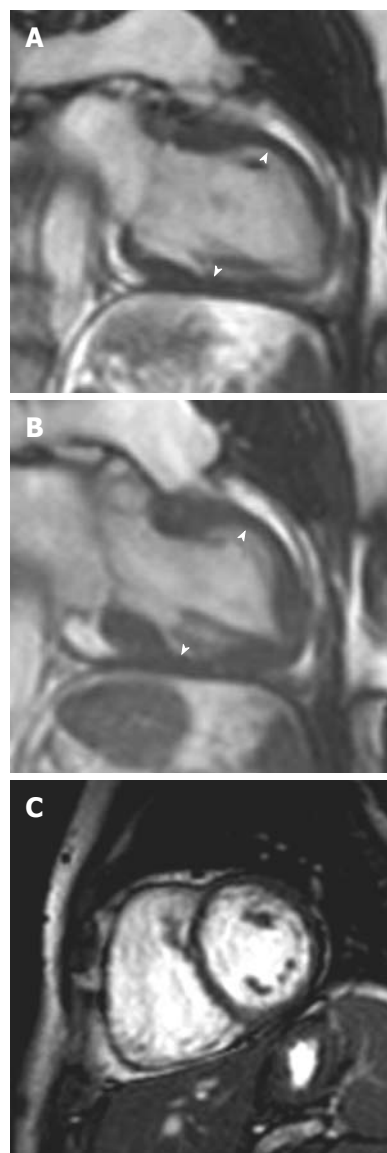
A 54-year-old woman with acute onset chest pain and palpitations following a road traffic accident. A, B: Vertical long-axis SSFP sequence in (A) diastole and (B) systole showed akinesia of the left ventricular myocardial segments at the midventricular level; C: Late gadolinium enhancement showing no myocardial enhancement in the involved segments. Subsequent echocardiography 1 mo later showed normal mid-wall contraction.
